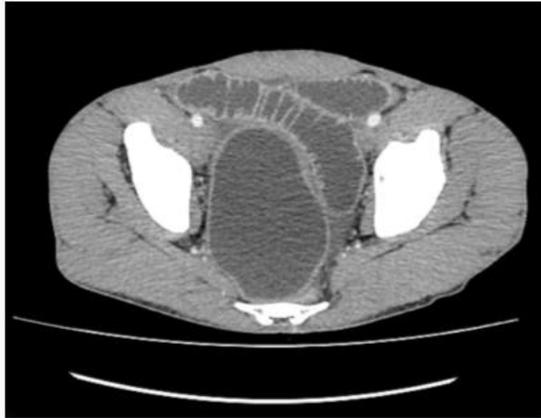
CT image showing pelvic hydatid cyst with distended ileum
